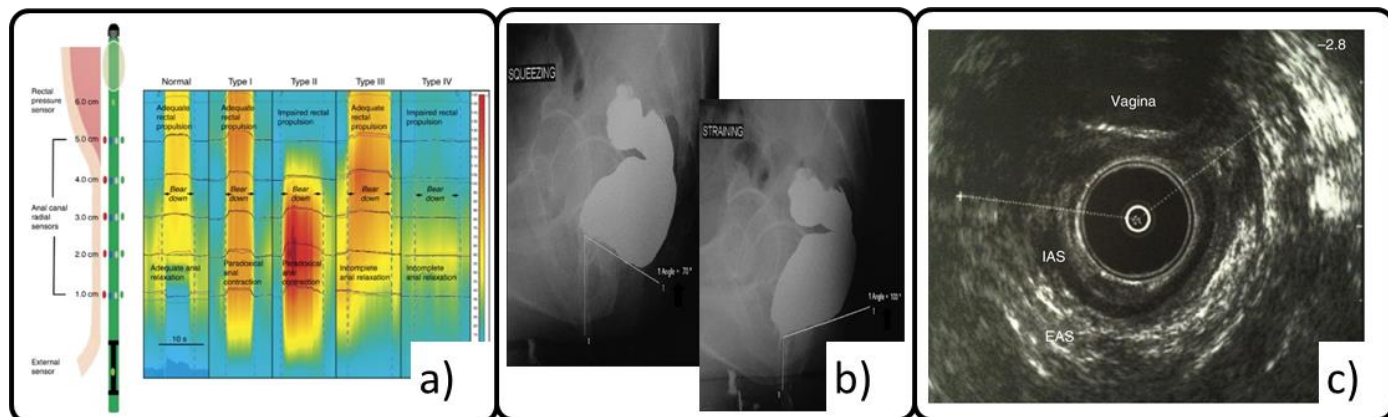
Outputs from key clinical tools used to assess and diagnose FI a) high resolution anorectal manometry shows the pressure distribution along the anal canal (14) b) evacuation defaecography shows movement of anatomical structures and anorectal angle change during defecation, helping to highlight abnormalities (15) and c) endoanal ultrasonography provides cross-sectional views of the anal canal enabling identification of muscle and soft tissue defects (16).
